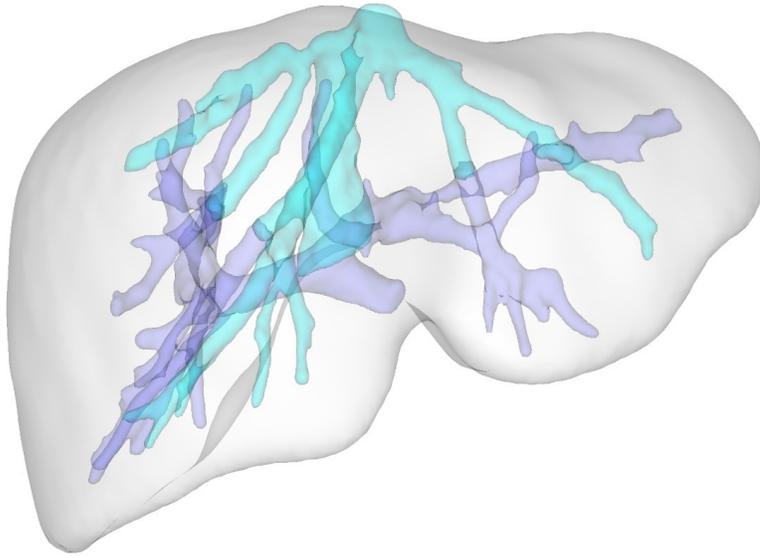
From contrast enhanced CT data, automatic definition of liver parenchyma was performed with subsequent user assisted confirmation of accurate organ segmentation. Hepatic veins (aqua) and portal veins (blue) are also defined
